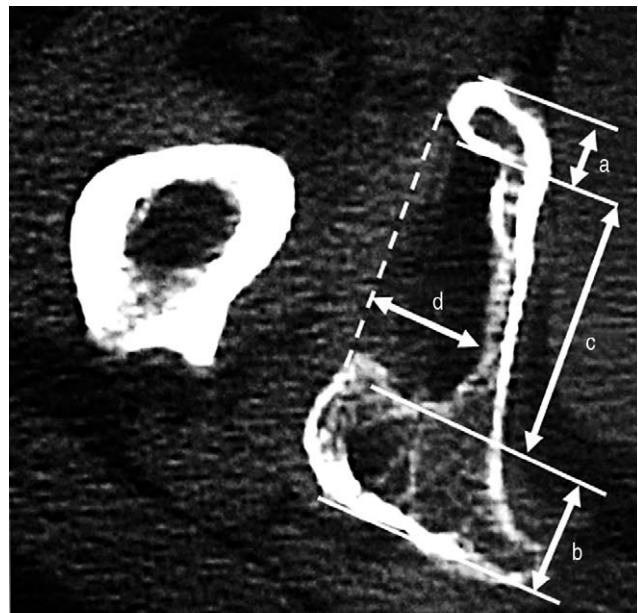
Thickness of the anterior wall (a) and posterior wall (b), width (c), and depth (d) of the original acetabulum were measured using preoperative computed tomography images in axial view.
